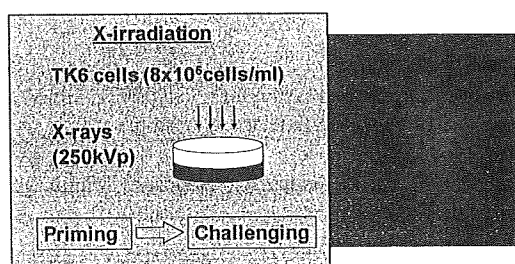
An experimental scheme for mutagenic radioadaptation. The optimum conditions providing the greatest reduction in the frequency of *TK* mutations induced after a challenging X-ray (2 Gy) irradiation of TK6 cells, are shown in the right panel of this figure. The details have already been described in our previous work.⁴³
